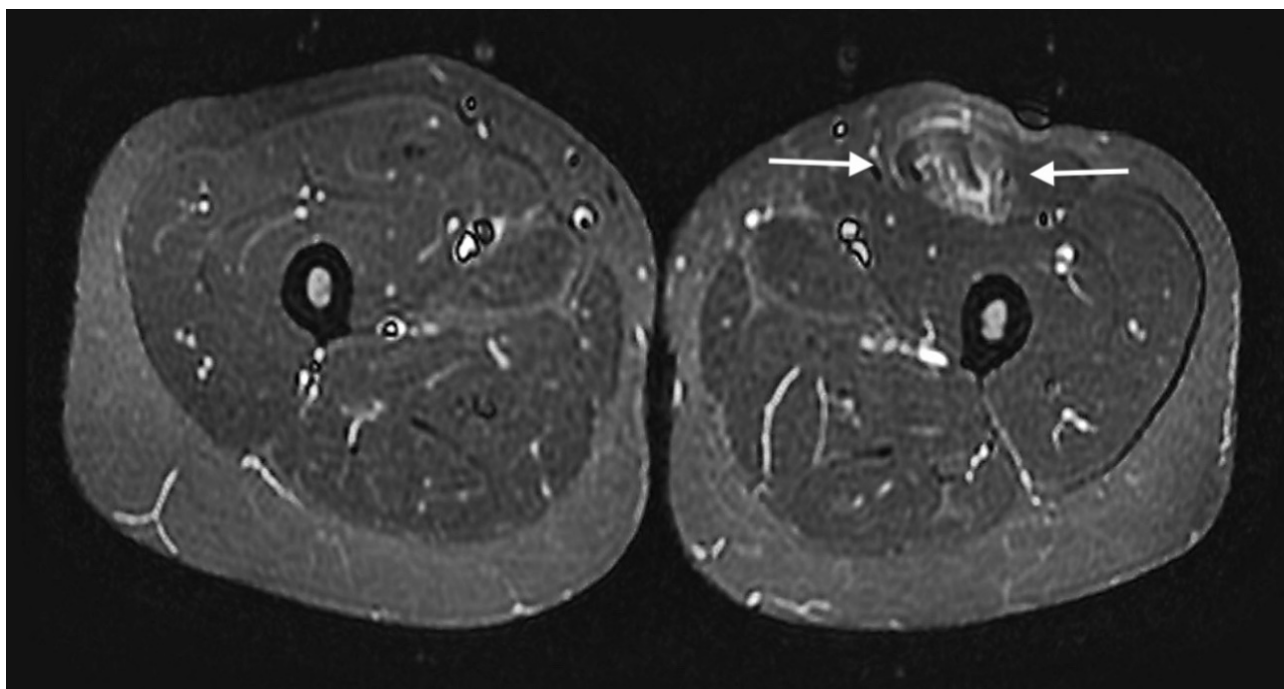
A 13-year-old male with sudden pain in the anterior region of the left thigh after kicking the ball. Axial short-tau inversion recovery MRI sequence of the thigh showing edema and architectural distortion of the myotendinous junction of the indirect rectus femoris tendon (arrows). SOMICS category 2 (score of 7).
